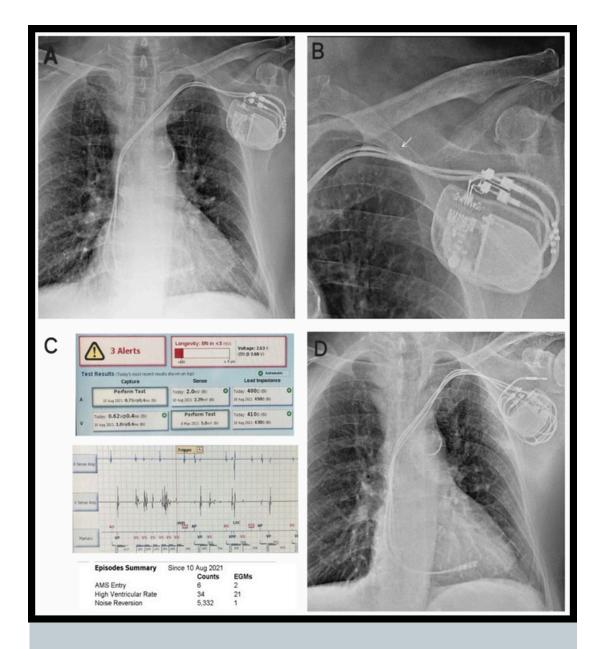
Case 2. (A) Chest radiograph showing the pacemaker device with right atrial and right ventricular leads in situ. (B) Zoomed view of the chest radiograph showing damage (white arrow) in right ventricular lead. (C) Device interrogation showing high ventricular rate alert with noise reversion suggestive of lead failure. (D) Chest radiograph post right ventricular lead revision showing capped old right ventricular lead and functional right atrial and new right ventricular leads.
